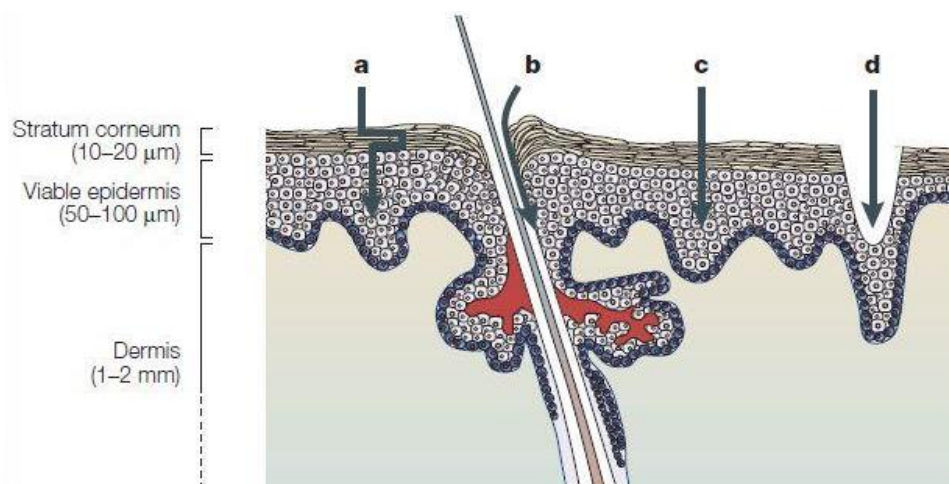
Mechanisms of transdermal delivery (a) Transdermal diffusion, passive and with chemical enhancer, follows a tortuous route across the stratum corneum (b) Low-voltage electrical enhancement by iontophoresis can make transport pathways through hair follicles and sweat ducts more accessible. (c) High-voltage enhancement by electroporation has been shown to occur via transcellular pathways made accessible by disrupting lipid bilayers. The application of ultrasound seems to make pathways (a) and (c) more permeable by disorganizing lipid bilayer structure. (d) Microneedles and thermal poration create micron-scale holes in skin. Adapted with permission from [26].
